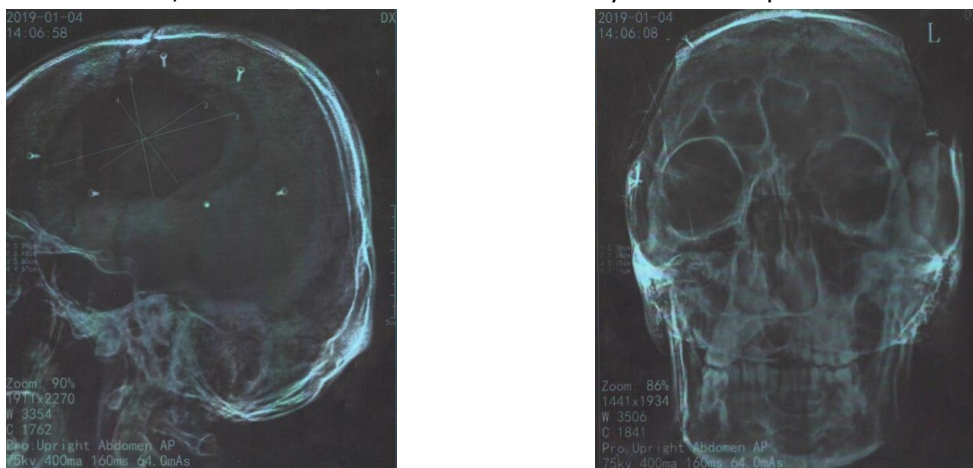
X-ray of the patient after surgery (fastening with titanium screws)
